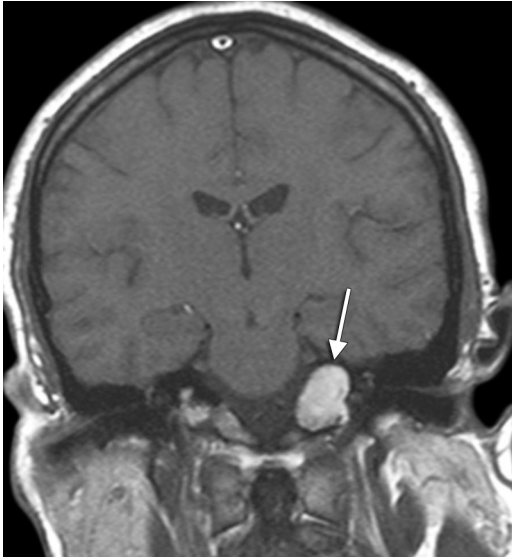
Cholesterol granuloma. Coronal precontrast T1-weighted MRI shows a lobulated T1-hyperintense lesion within the petrous apex (arrow).
